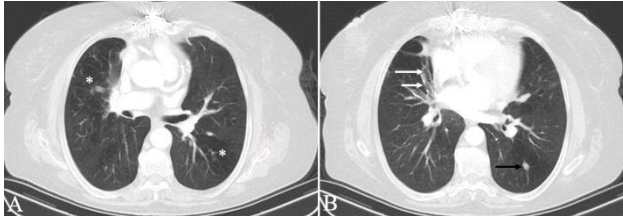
A 63-year-old male heavy-smoker with an obstructive PFT. Axial contrast-enhanced thorax CT images show mosaic attenuation pattern in bilateral lungs (asterisks, A) and bronchial wall thickening in the middle lobe of the right lung (arrows, B). Note that a micronodule in the lower lobe of the left lung (black arrow, B).
